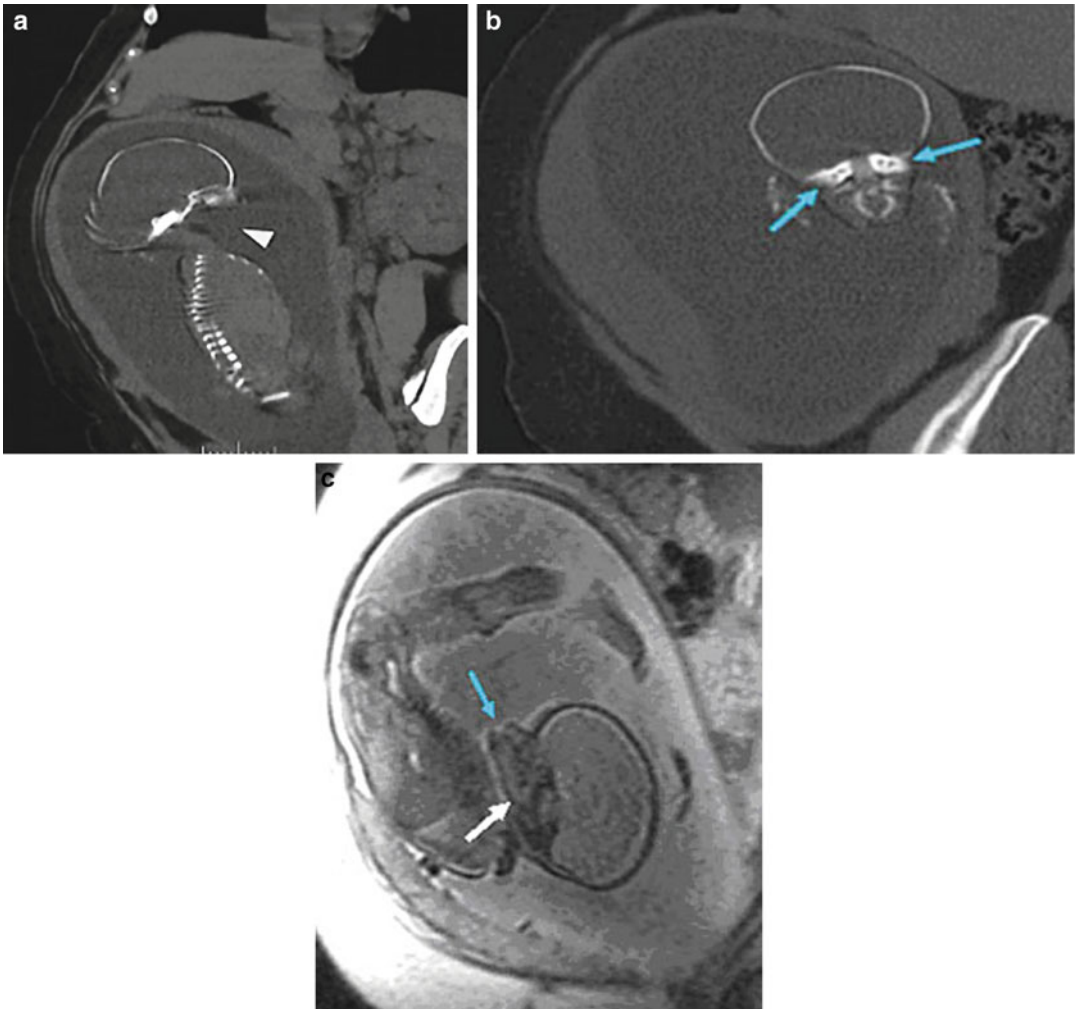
(a–c) Maternal abdominal T2 MRI showed agnathia (*blue arrow*) and the lower end of the large horizontal ear meeting at the jaw area (*white arrow*)
